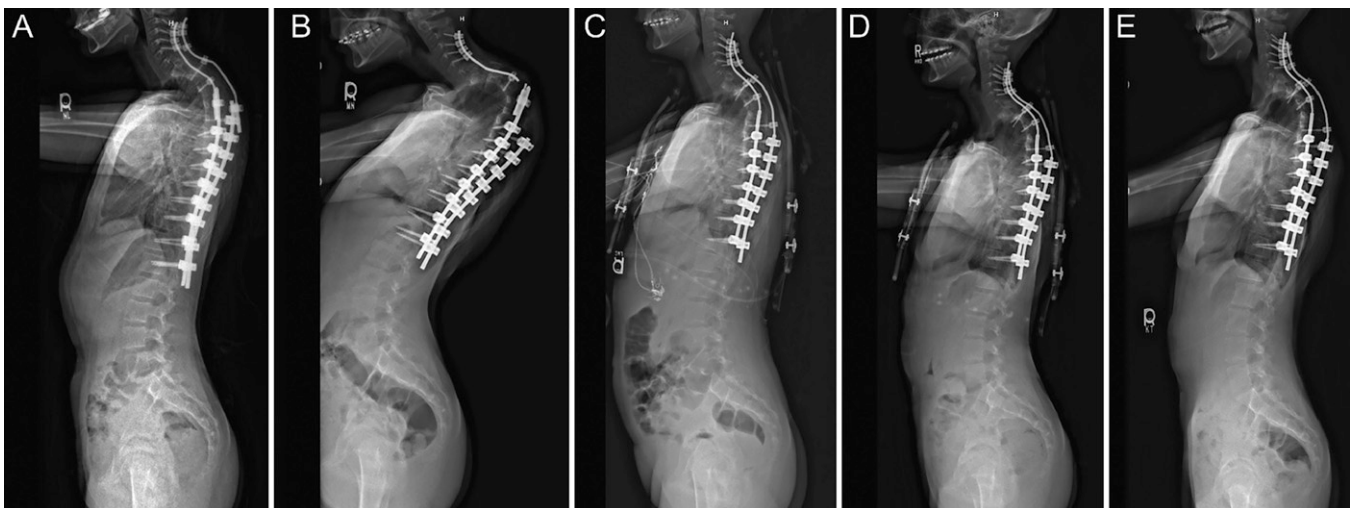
Standing lateral spine radiographs. A: After initial spinal fusion. B: After pseudarthrosis, instrumentation failure, and worsening of deformity. C: Postoperative day 1 after revision deformity correction. D: Postoperative 3-month follow-up. E: Postoperative 15-month follow-up.
